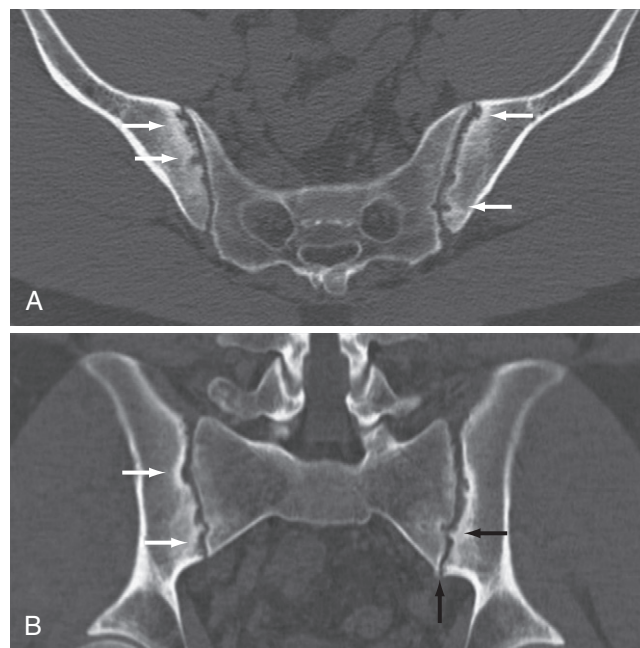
Bone erosion in sacroiliac joints in spondyloarthritis (computed tomography [CT]). Coronal (A) and axial (B) CT images of the sacroiliac joints in a patient with spondyloarthritis. Bone erosions (white arrows) and mild sclerosis and new bone formation (black arrows) are seen.
